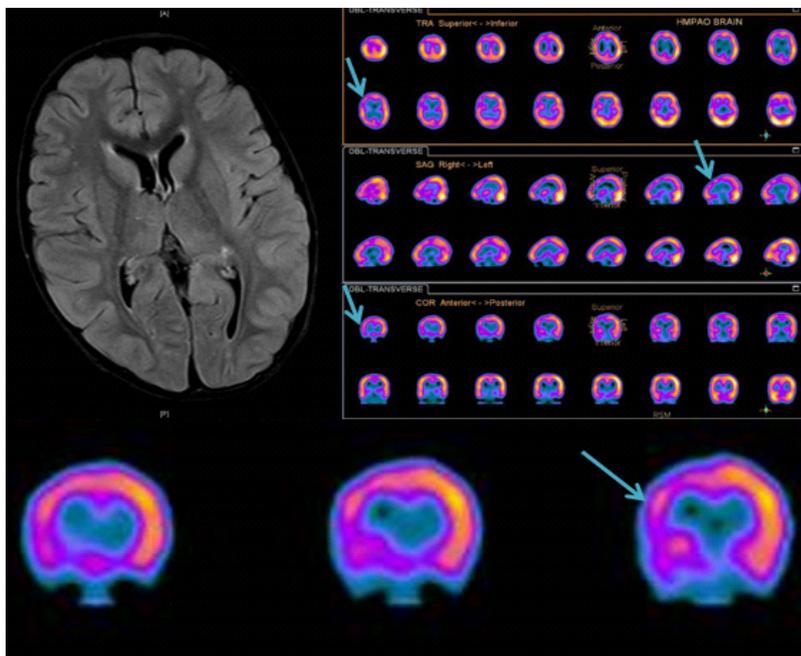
Viral meningoencephalitis: A 4-year-old female patient with left sided weakness. Picture of encephalitis. SPECT: Decreased regional cerebral blood flow in right frontoparietal hemisphere. Normal MRI (Not shown).
